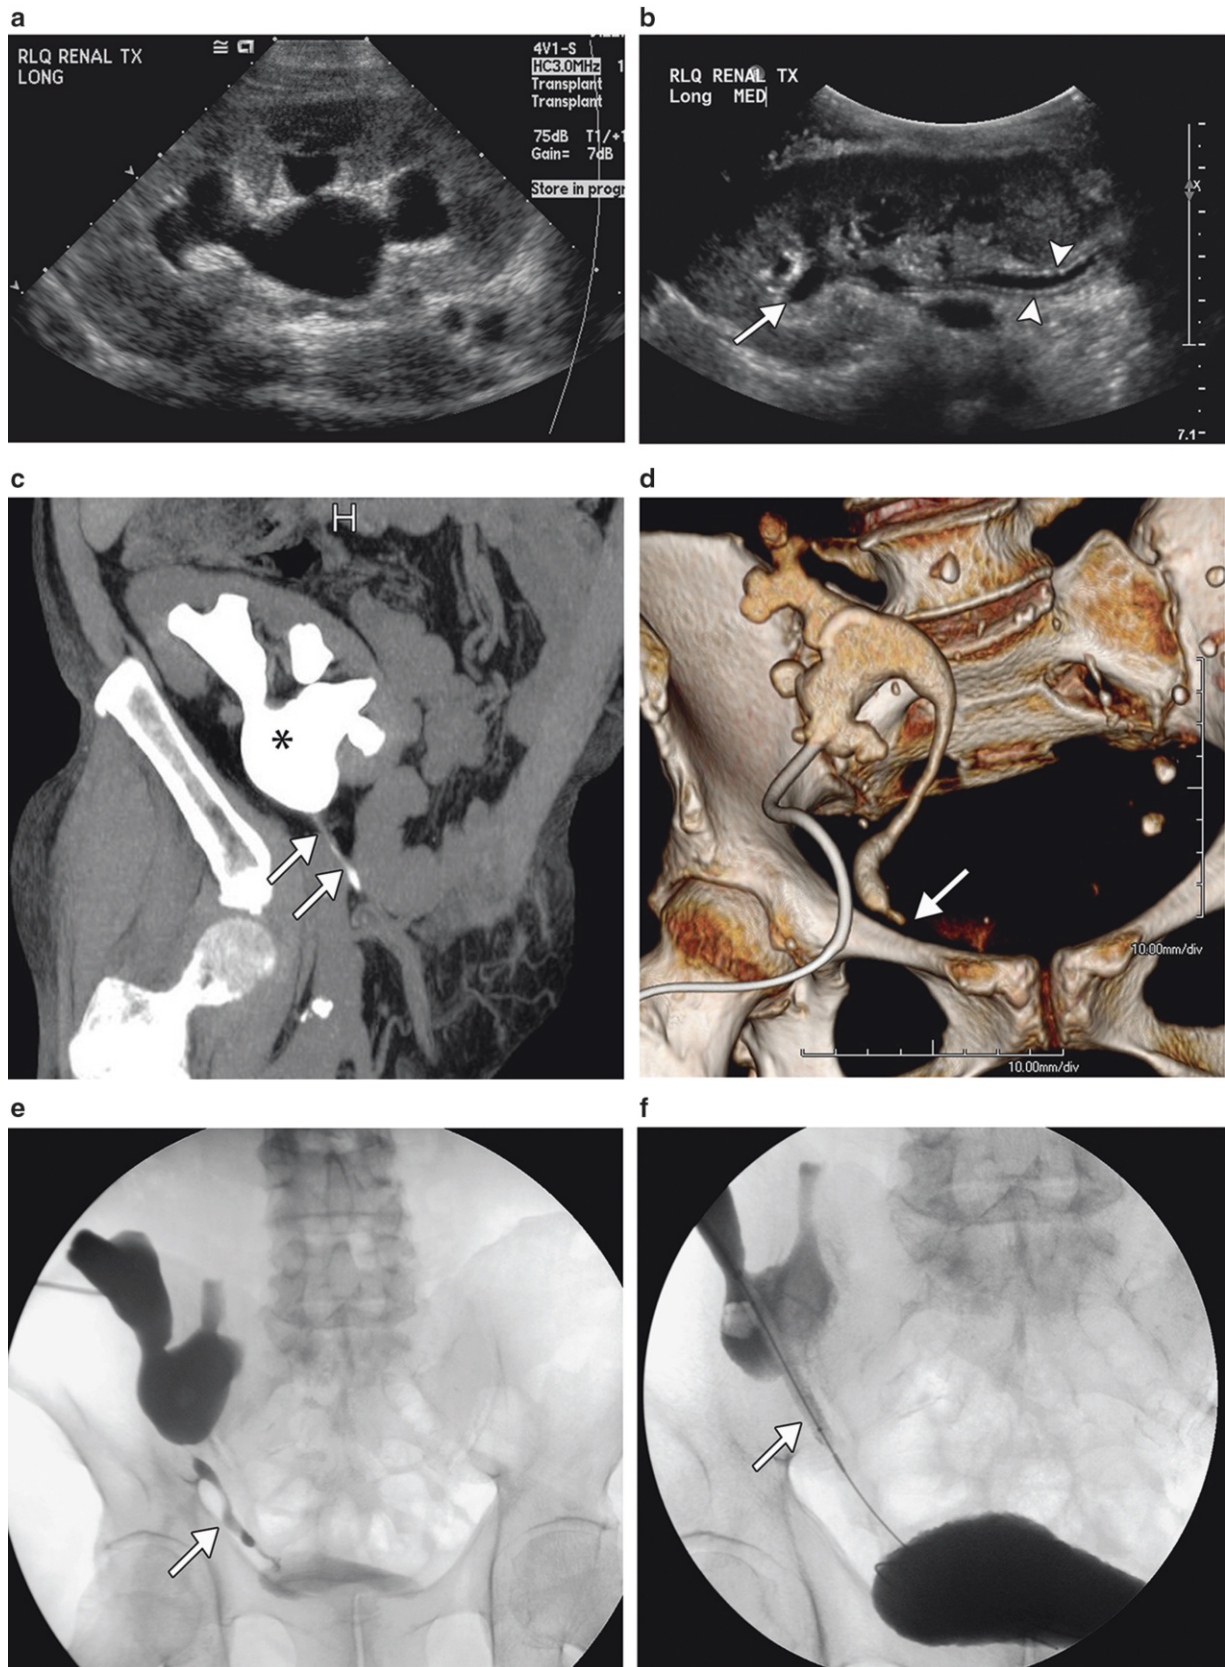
(a) Gray scale ultrasound shows fluid within dilated calyces and renal pelvis. (b) Longitudinal gray scale image along the course of a ureter shows hydroureter with wall thickening (*arrowheads*) and mild hydronephrosis (*arrow*). (c) CT nephrostogram showing diffuse ureteral
